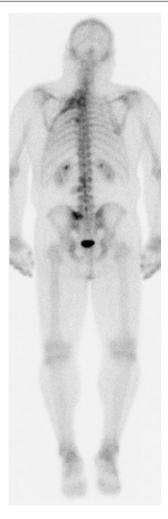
Bone scintigraphy demonstrating increased uptake at multiple levels, L2 and L3 vertebrae consistent with lesions of fibrous dysplasia (personal library)
